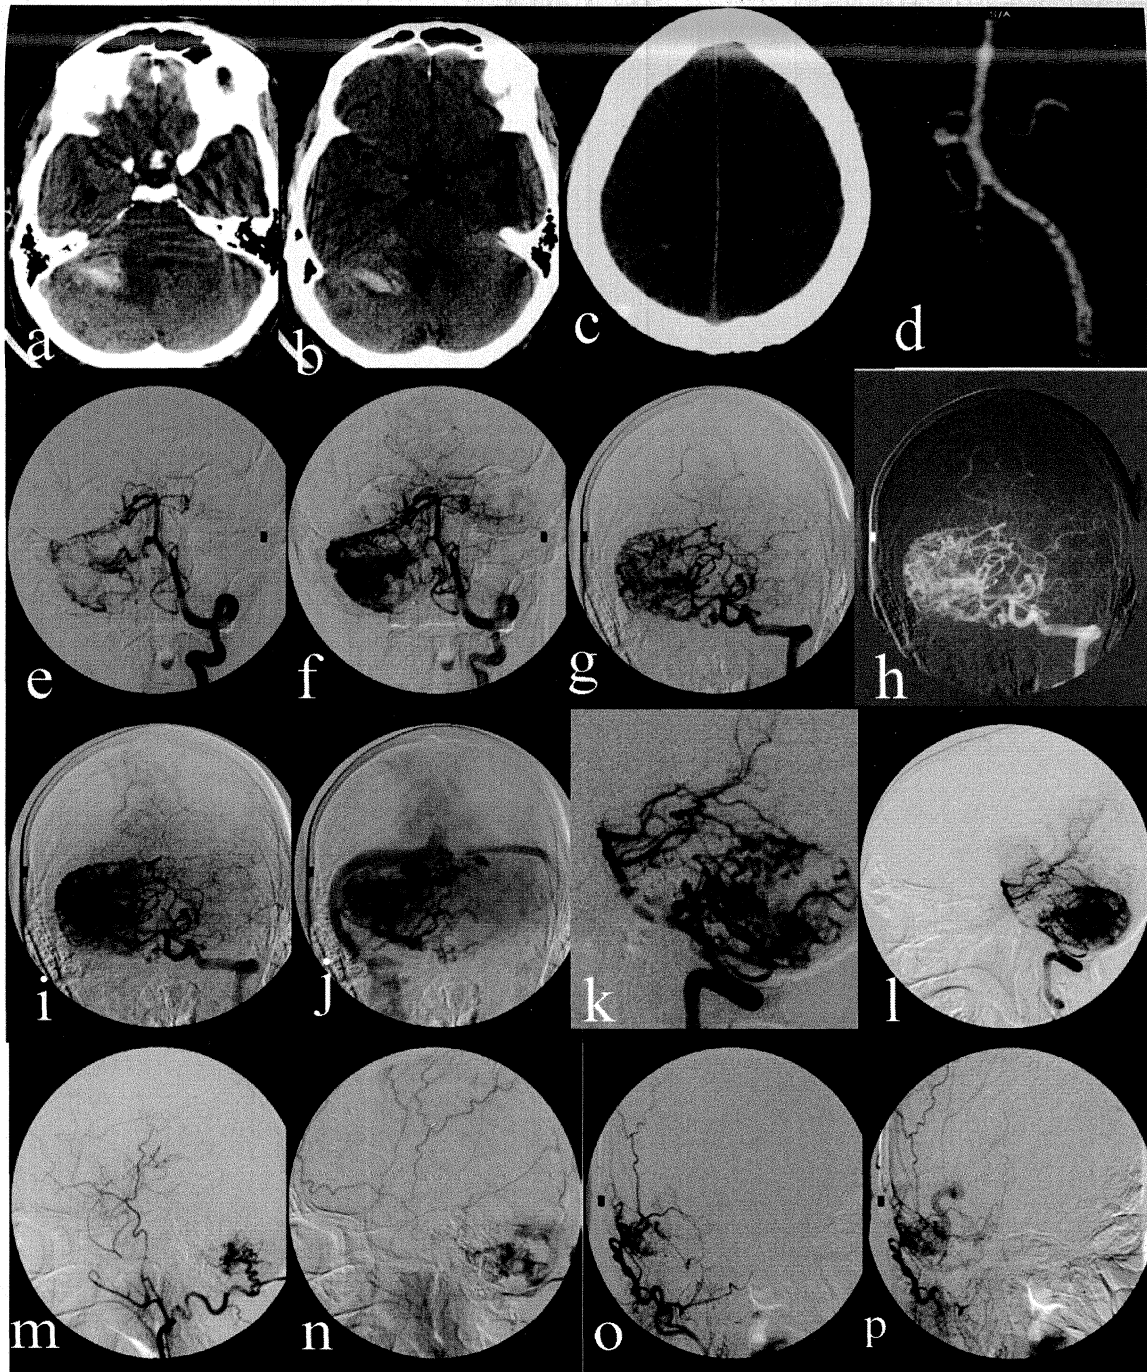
45 year old presented with sudden onset headache, giddiness, vomiting and LOC for 10 minutes. CT revealed Right cerebellar hematoma (a, b) and SAH (c). CTA was s/o right cerebellar AVM with a nidus measuring 2.2 x 1.8 cm with multiple aneurysmal sacs seen within. Flow related saccular aneurysm seen arising from the basilar artery proximal to the right AICA origin (d). DSA (e-p) showed a diffuse right cerebellar mixed pial-dural AVM with right AICA feeding artery aneurysm. The feeders were from SCA, AICA (e-h), right occipital artery(m-p); predominantly from AICA and draining into vein of Galen and deep veins and torcula (i-l). Right AICA is supplying the ipsilateral PICA territory (e).
